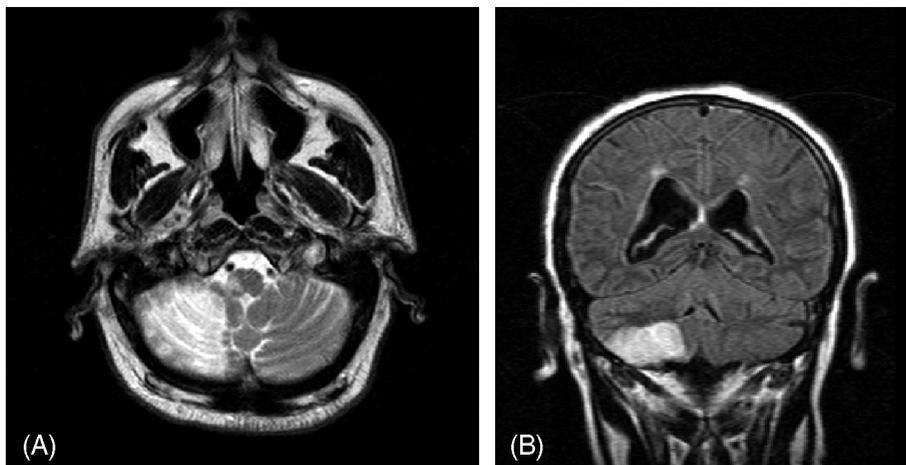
MRI scan showing an infarct in the territory of the posterior and inferior cerebellar artery involving the cerebellum and the dorsolateral portion of the medulla.
